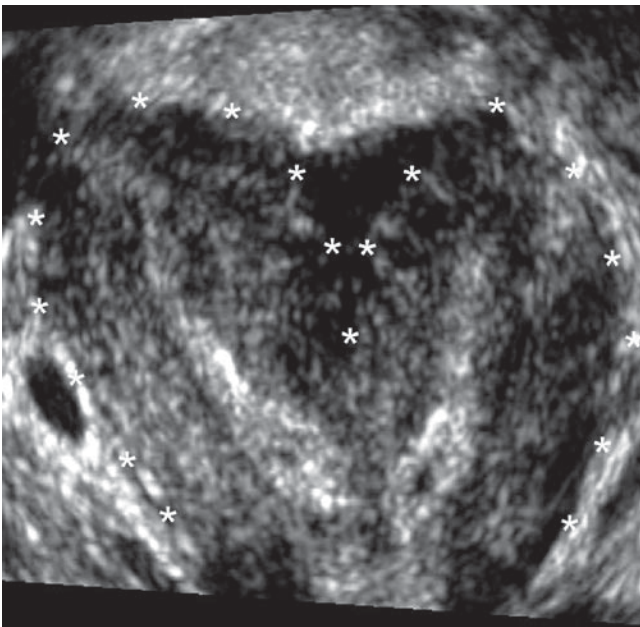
Uterine didelphys by 3D ultrasound showing outline of didelphys uterus (*) and bright endometrial stripes
